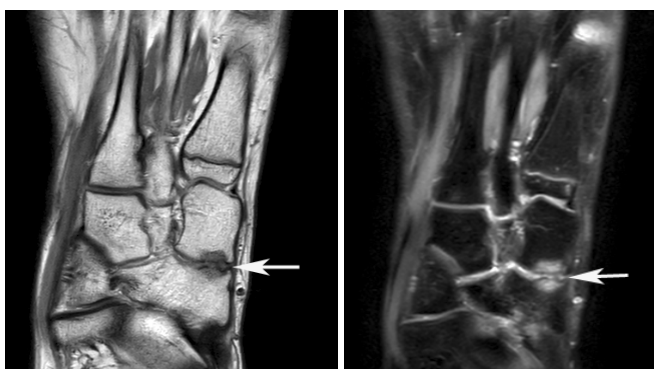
Axial PDW FSE and fat suppressed PDW FSE MR images showing fluid SI at the coalition (arrows) consistent with a synchondrosis, and reactive oedema-like marrow changes in both bones.
